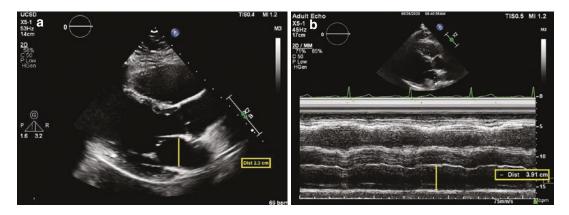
(a) Parasternal long-axis view demonstrating linear size measurement of the left atrium (*yellow line*). (b) M-mode imaging of parasternal long-axis view demonstrating linear size measurement of left atrium (*yellow line*)
